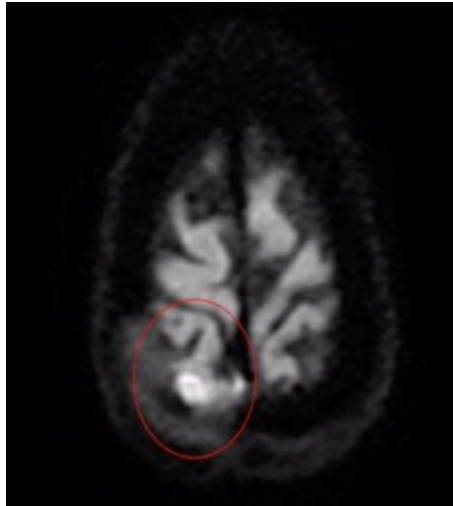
Patient 2-MRI brain showing infective granulation in Rtparietalregion
